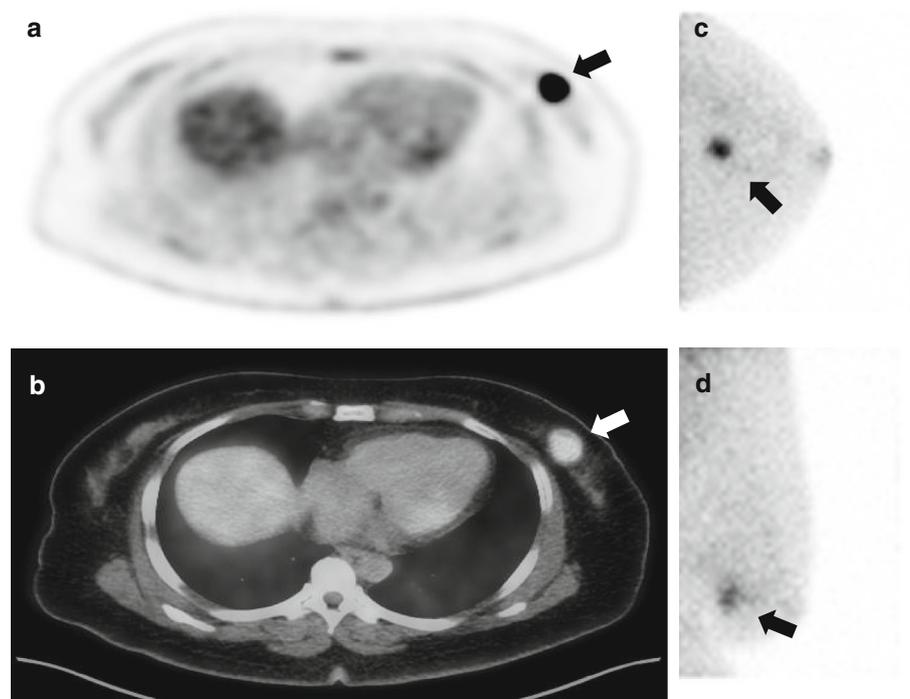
A 47-year-old patient diagnosed with invasive ductal breast cancer (SUV_{max} 22.3, TNR 5.73, positive ANS, pTS 21 mm, negative ER). In a PET and b transaxial fusion view of ^{18}F FDG PET/CT, a hypermetabolic lesion in the lower outer quadrant of left breast and a lymph node with focal FDG uptake in the left axillary area were shown. c CC view and d MLO view of BSGI demonstrate focal uptake in the lower outer quadrant of left breast (*arrows*). This patient had a recurrence in the left cervical lymph node after 18.3 months
